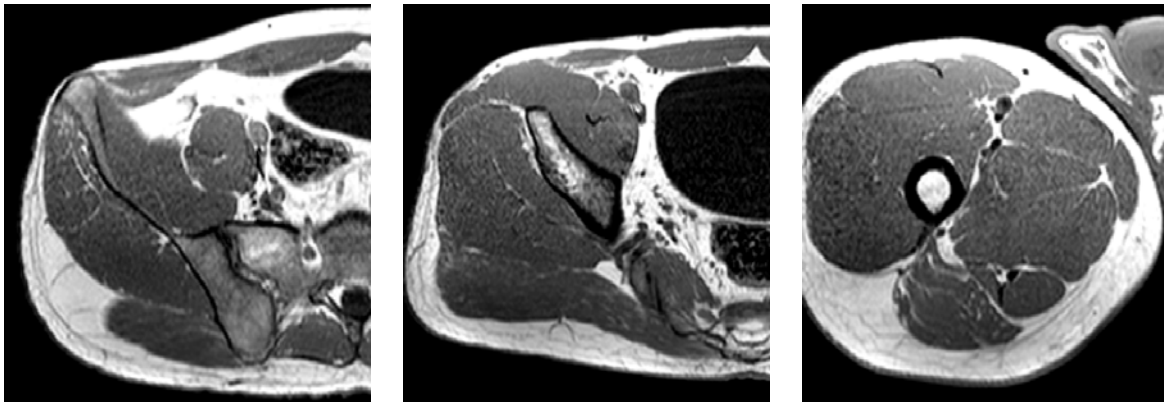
Sample slices from T1-weighted MRI showing variety of bones structures: parts of the pelvis (*left, middle*); middle part of the femur with broad (black) cortical bone (*right*)
